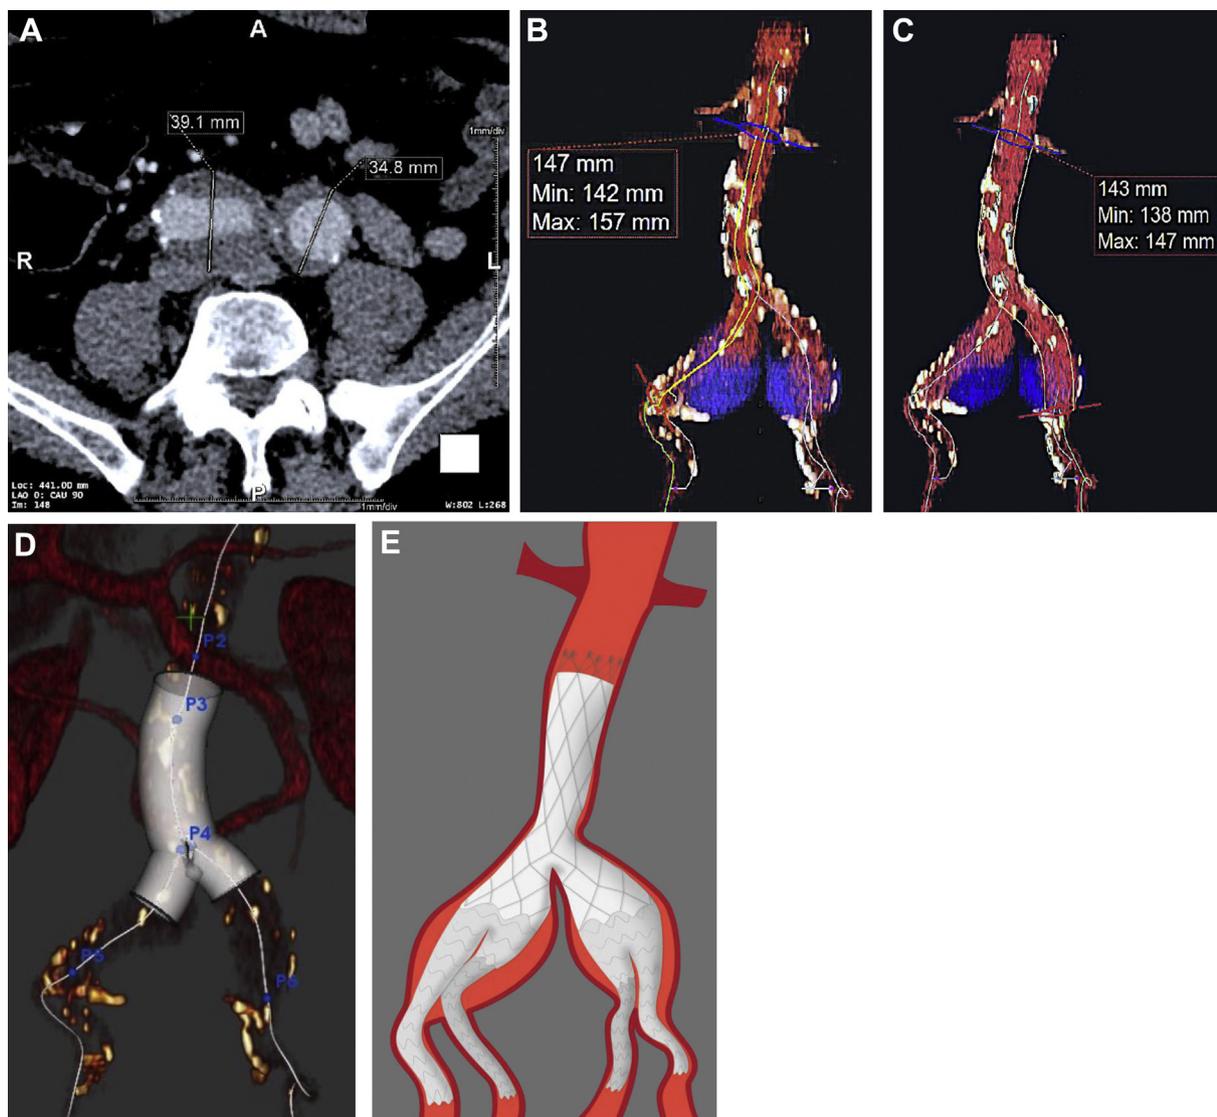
Preoperative imaging, measurements, and planning. A, Expanding bilateral common iliac artery (CIA) aneurysms measuring 35 to 40 mm on computed tomography angiography (CTA). B and C, Centerline three-dimensional reconstruction measuring the distance of the lowest renal artery to (B) the right internal iliac artery (IIA) as 147 mm and (C) the left IIA as 143 mm. D, The interventional roadmap for AFX endograft deployment. E, Preintervention planning to use a bifurcated unibody aortic endograft to reconstruct the aortic bifurcation, allowing deployment of iliac branch endoprosthesis (IBE) to repair bilateral CIA aneurysms.
